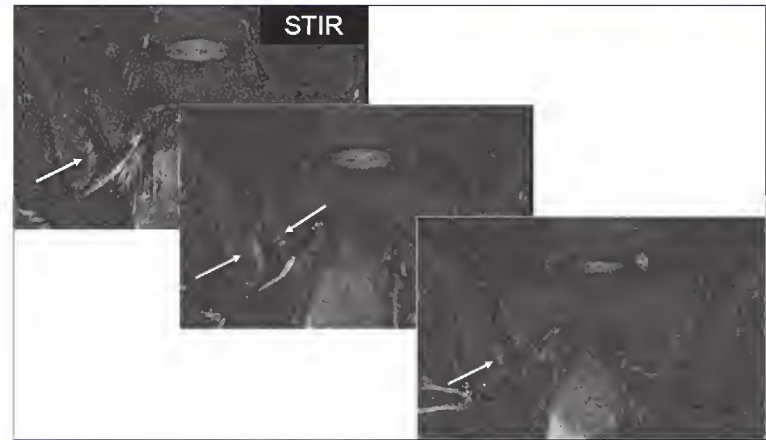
Example of a positive finding on magnetic resonance imaging of the sacroiliac joints in axial spondyloarthritis. When only one lesion is seen, this lesion must be present in at least two consecutive slices (arrows).
